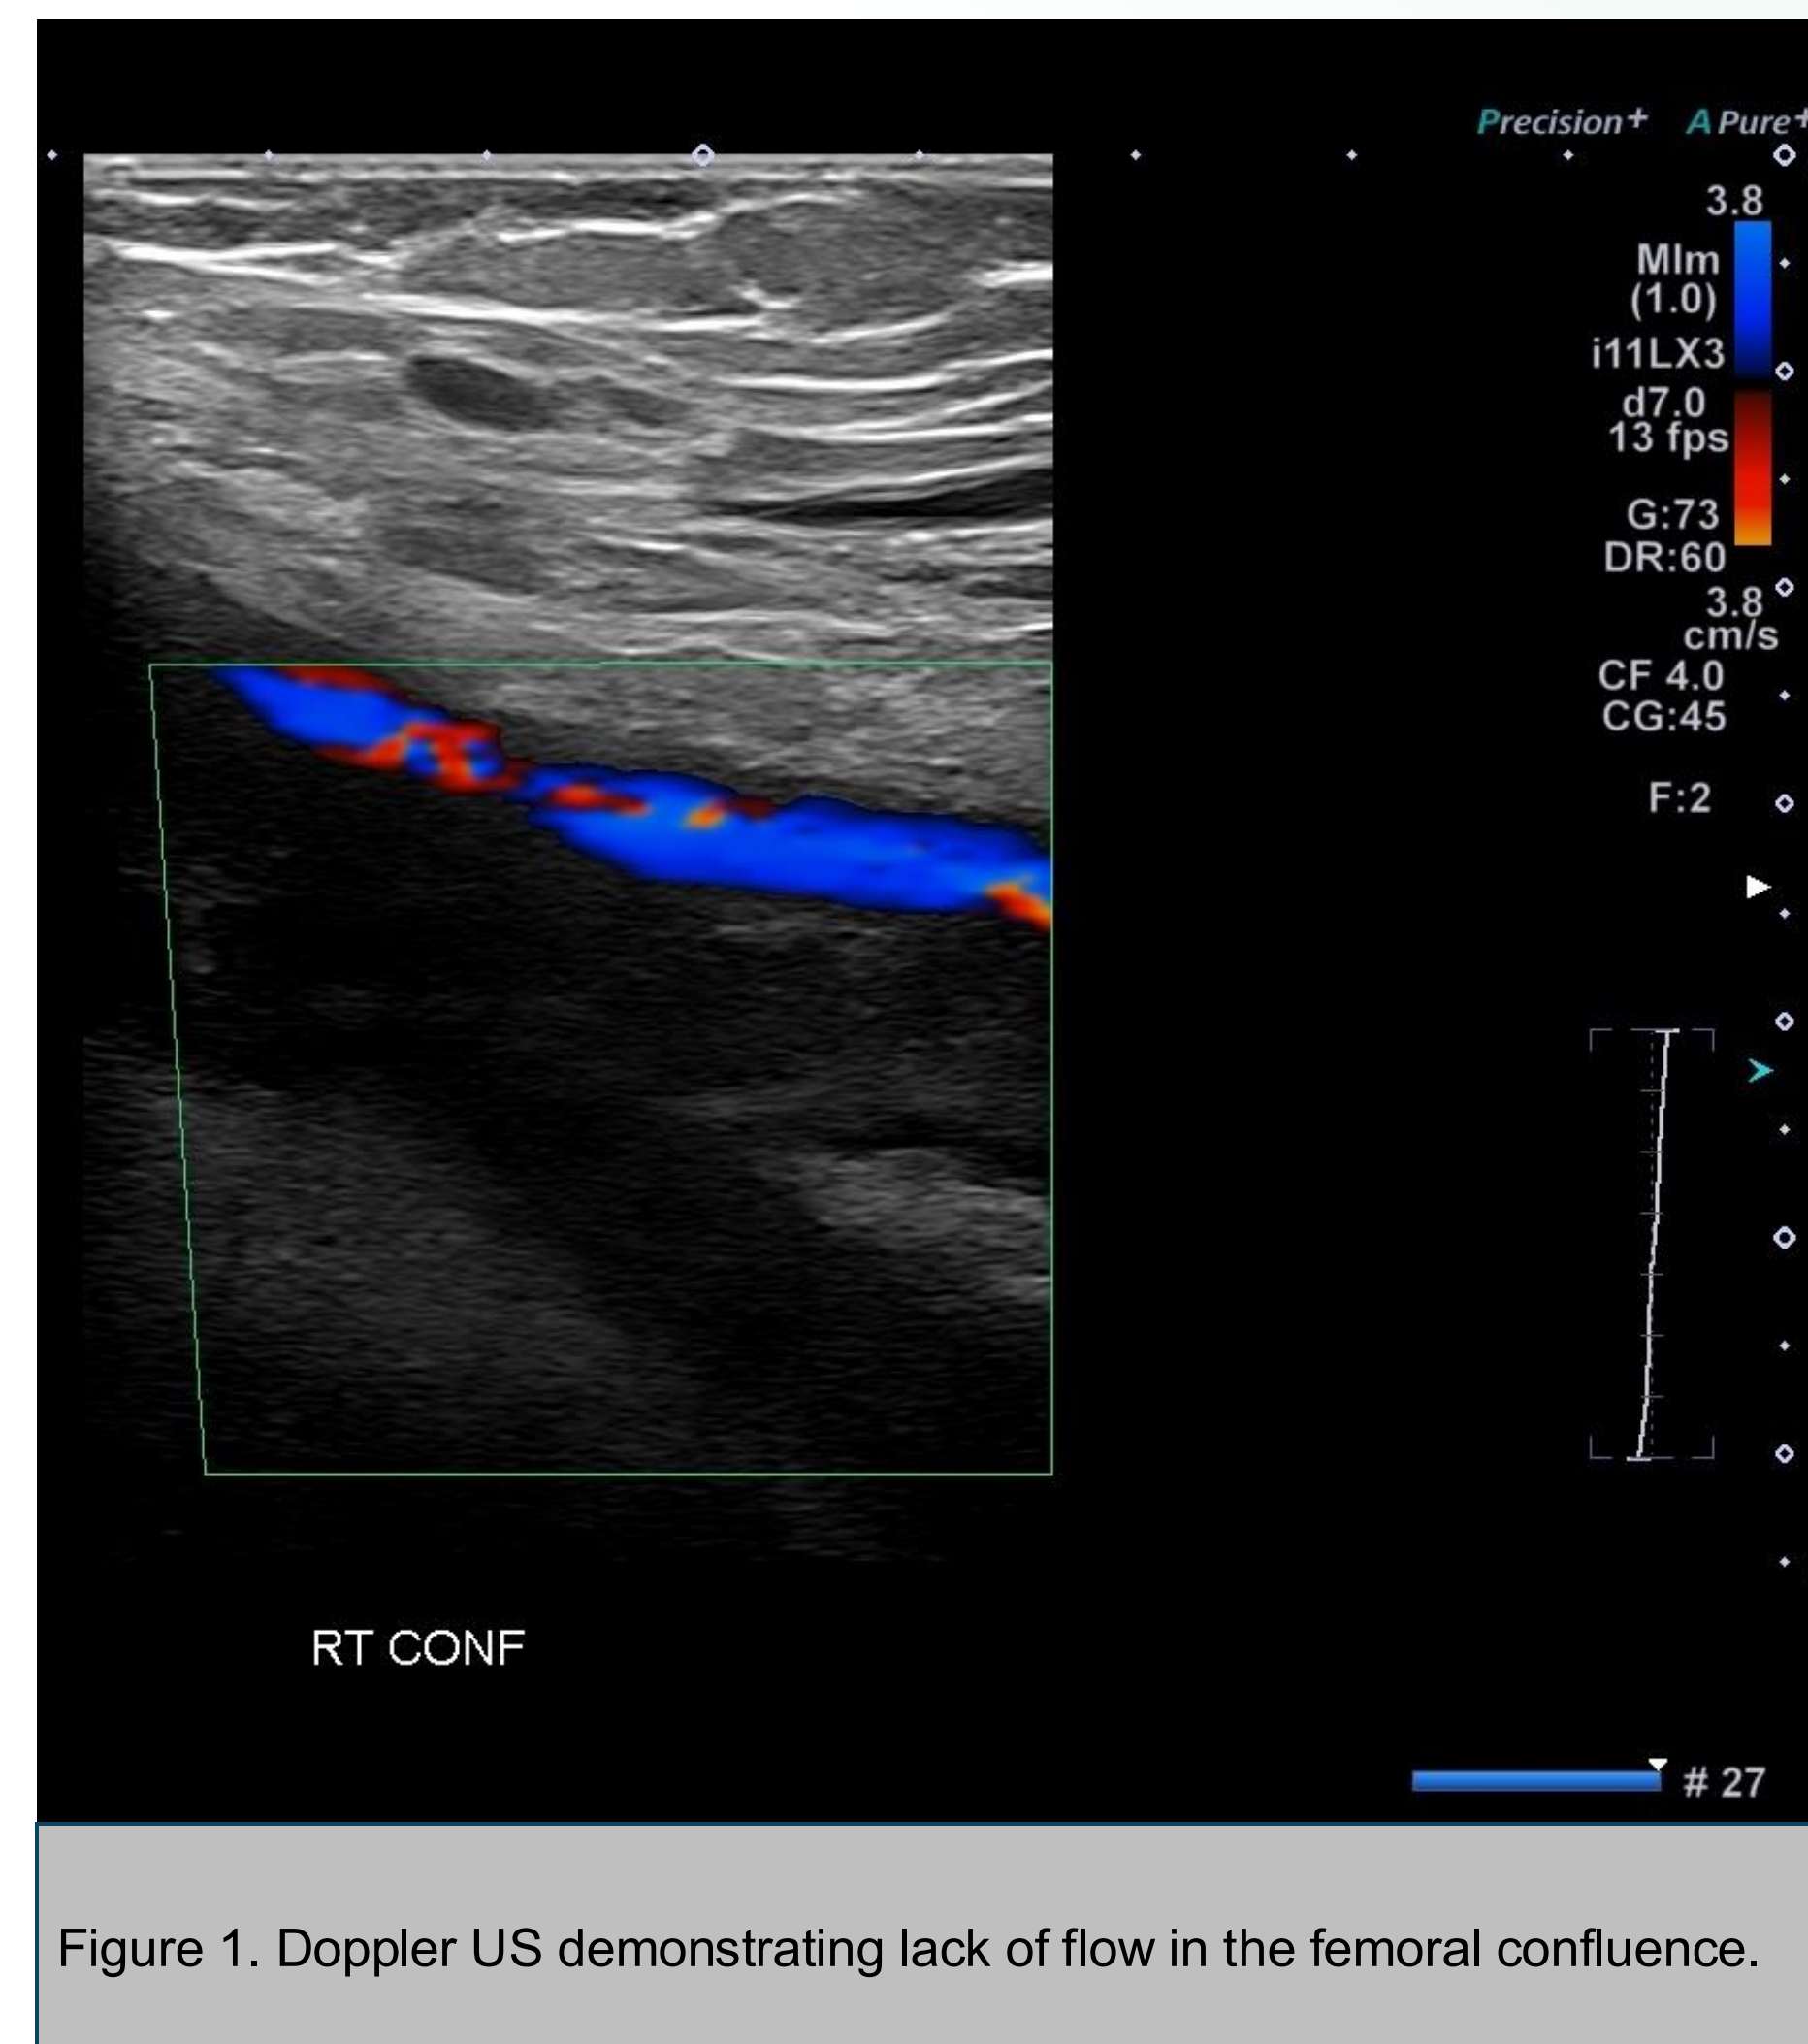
Doppler US demonstrating lack of flow in the femoral confluence.
